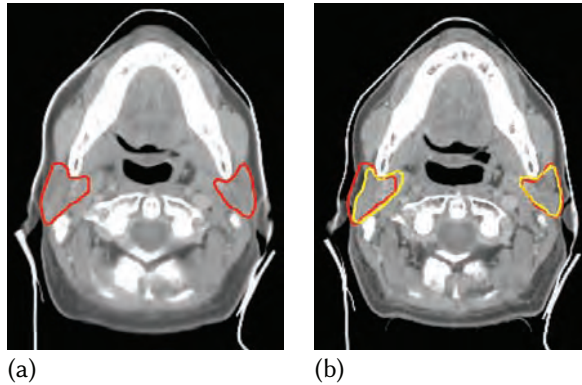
Patient with unilateral irradiation (right neck). (a) planning CT scan. Red contours: parotid glands. (b) post-EBRT CT scan. Yellow contours: parotid glands after treatment. Red contours: parotid glands before treatment.
